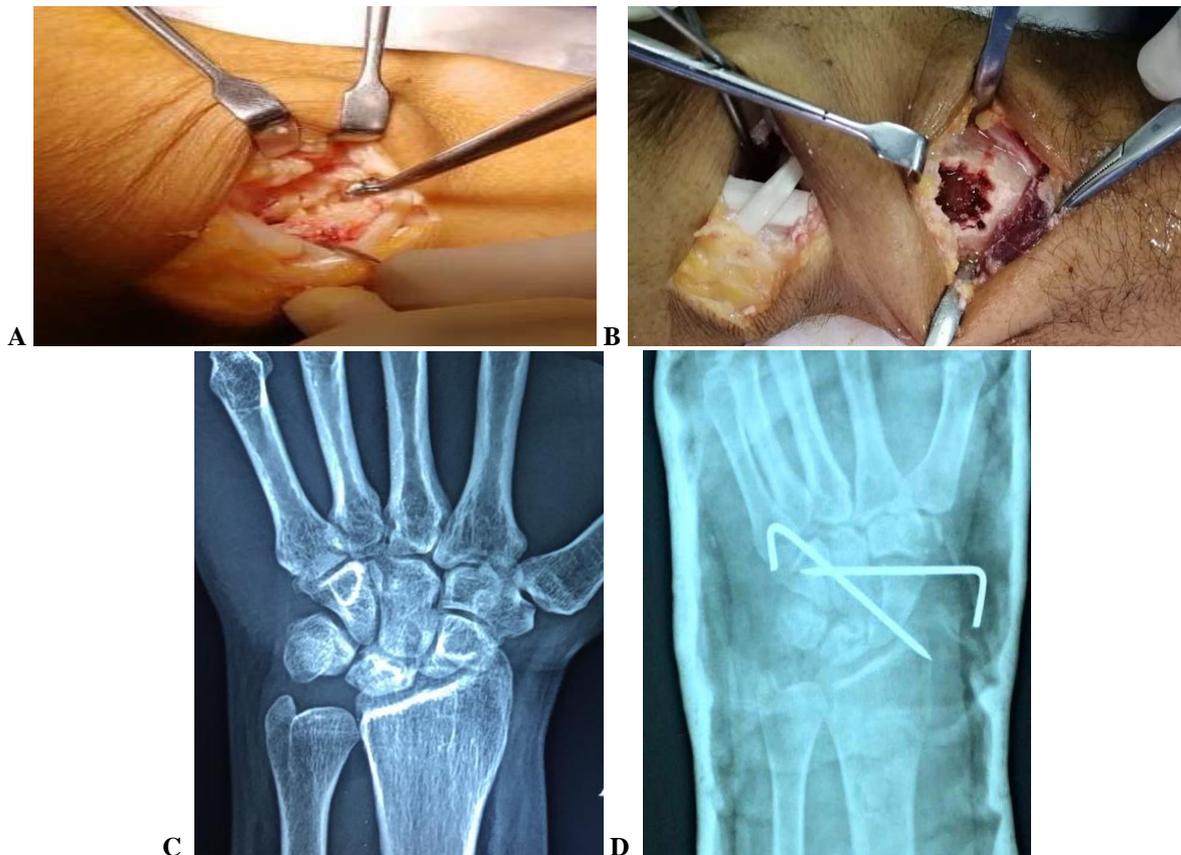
(A) Decortication of scaphoid and capitate bones. (B) Grafting from the floor of the second extensor compartment. (C) Pre-operative x-ray of the patient with grade IIIA Kienbock disease. (D) Post-operative x-ray showing scapho-capitate fusion.
